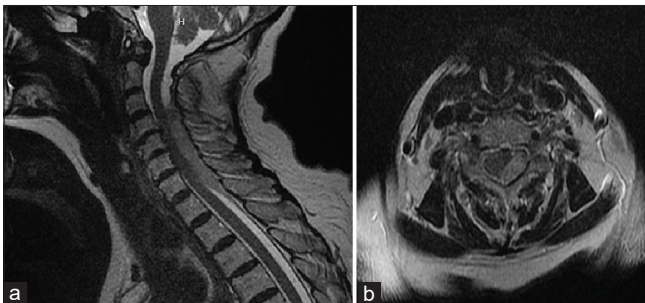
T2-weighted MRI of the cervical spine showing (a) sagittal view of compressive epidural hematoma and (b) axial view of the left eccentric epidural hematoma causing spinal cord compression.
